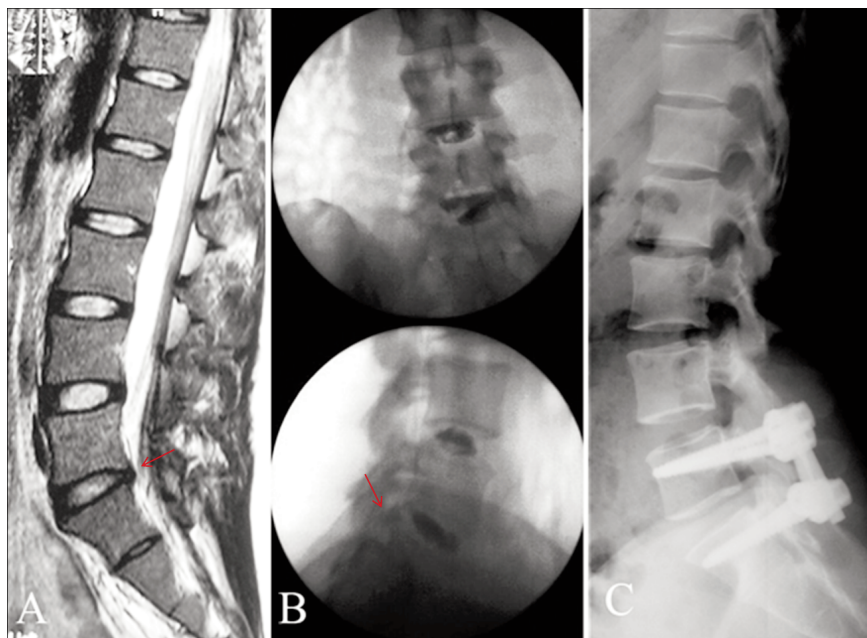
A) Sagittal T2-weighted magnetic resonance imaging showing degeneration of the L5-S1 intervertebral disc and mild loss of lumbar lordosis; B) Discography demonstrating the annulus fibrosus tear of the L5-S1 intervertebral disc; C) A postoperative lateral lumbar radiograph of the patient.
